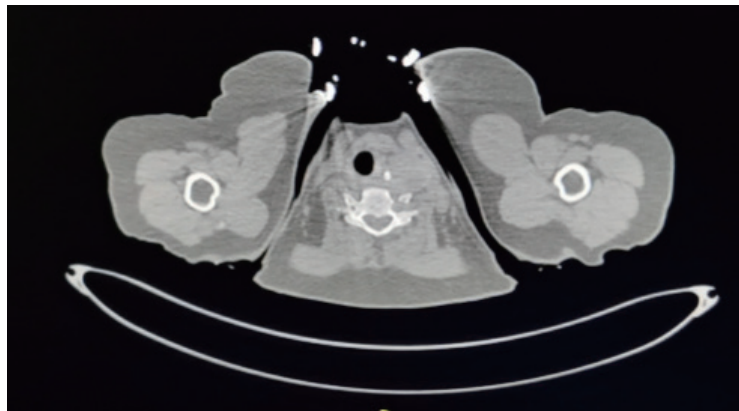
The patient's CT (1. The largest nodule is in the left lobe of the thyroid; the size of nodule is about 4.2*3.5cm. 2. The structure of the trachea and esophagus moves to the right under pressure)
